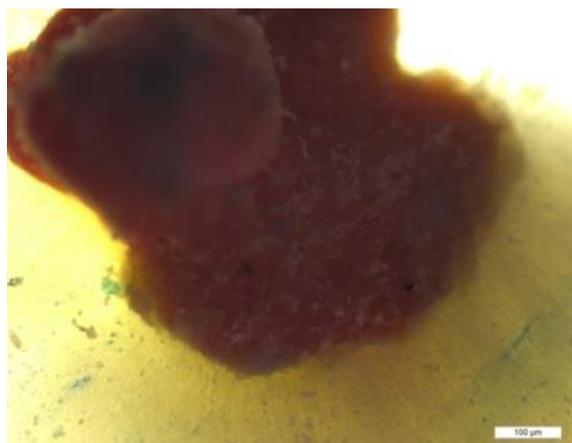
Thermo treated gutta-percha associated to ultrasonic vibrations shown a superior grip to the dentin walls hindering the penetration of methylene blue; this tooth is scored with 0 points (magnification x20)
